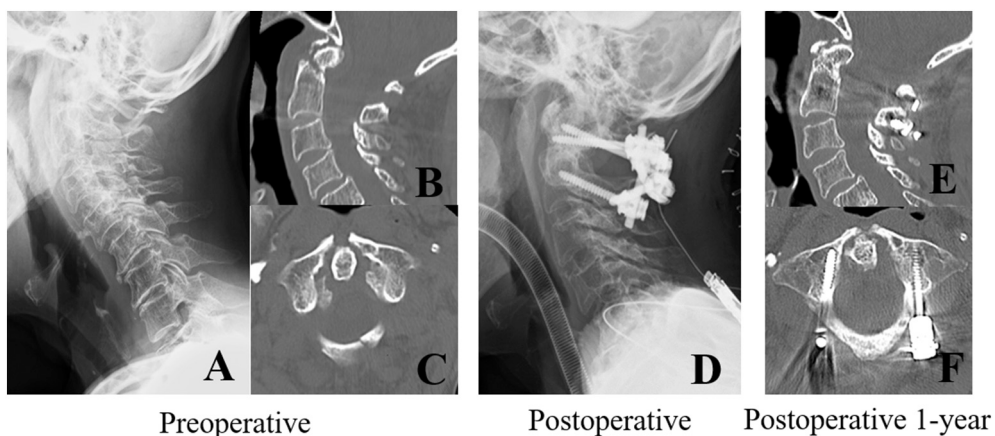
Preoperative radiograph (A: lateral view) and CT imaging findings of the cervical spine (B: sagittal view C: axial view of C1) showing a Jefferson fracture and type II odontoid fracture. We performed posterior fixation of C1–2 (D: lateral view). The CT imaging of cervical spine at 1 year following surgery showing the bone union of fracture location (E: sagittal view F: axial view of C1).
